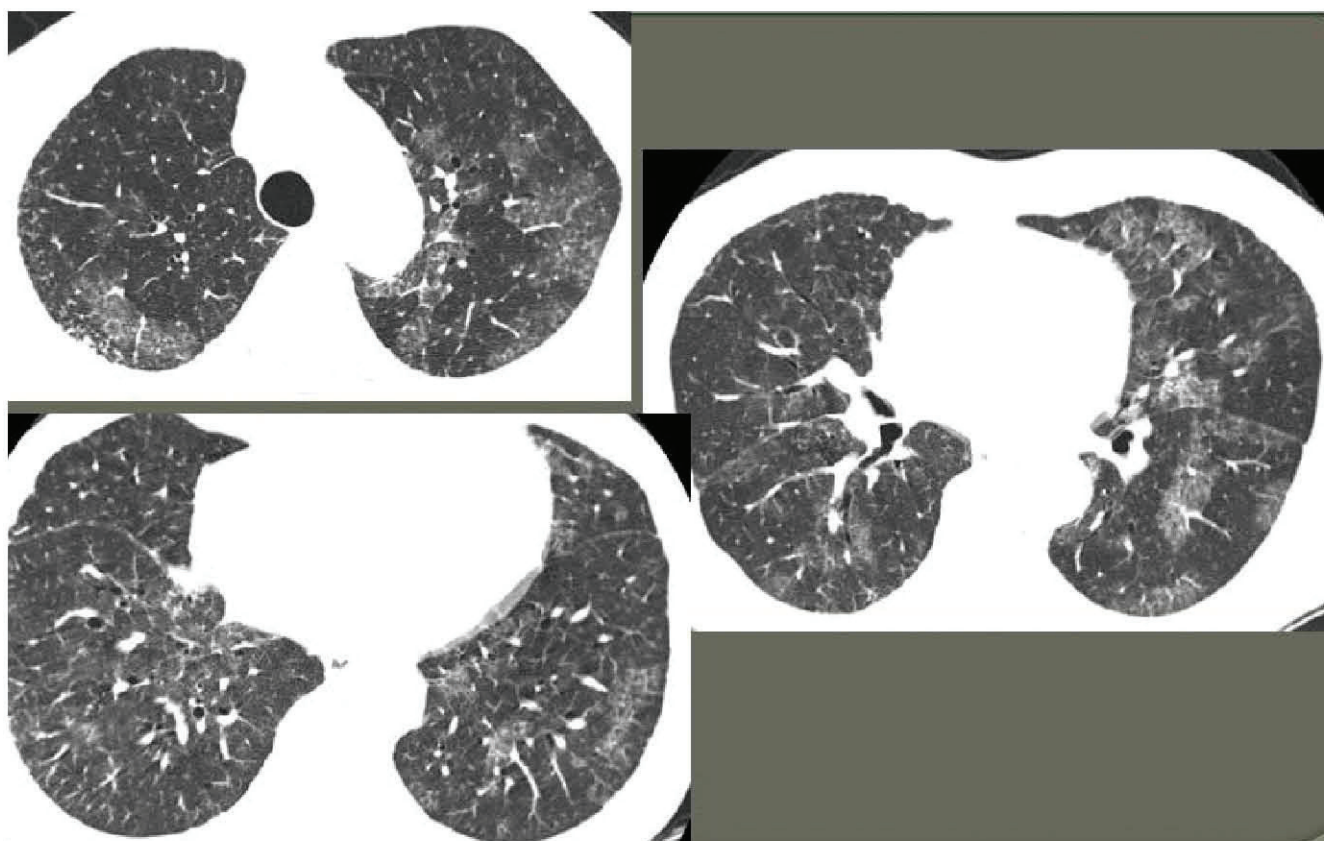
HRCT after first bilateral WLL
